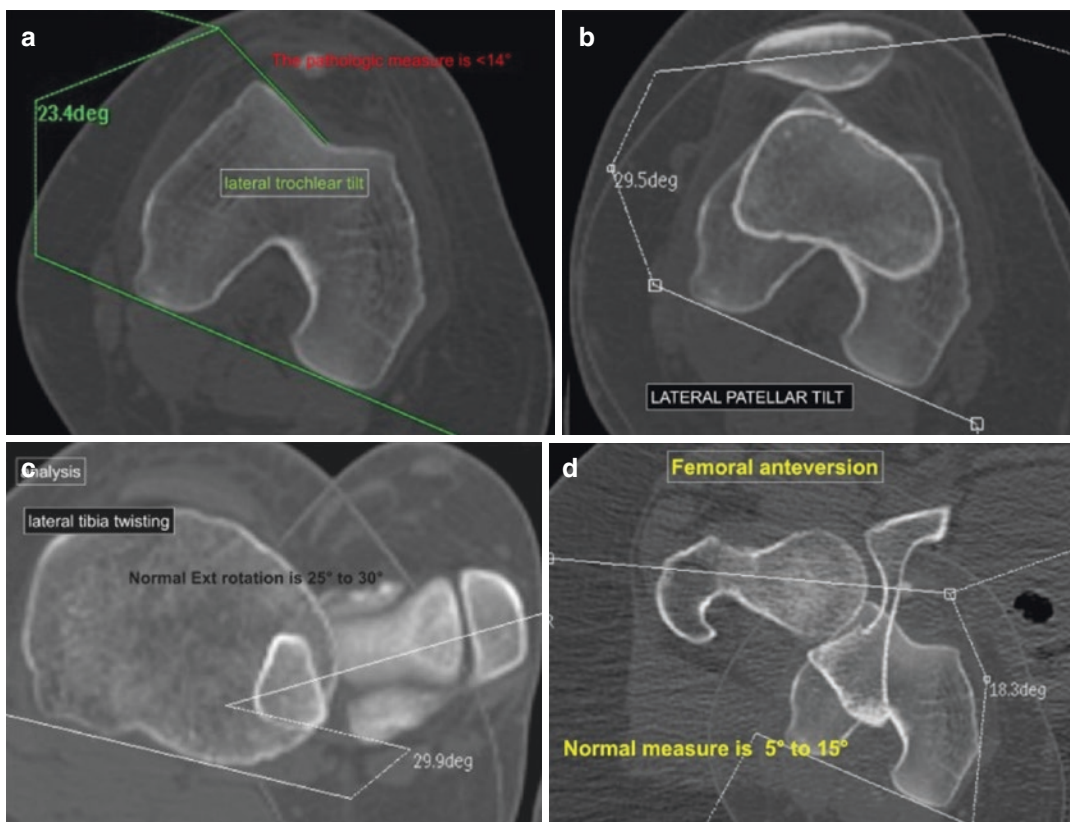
Rotational profile CT images to demonstrate the multiple anatomical factors involved in destabilising the patella, including (a) lateral trochlear tilt, (b) lateral patellar tilt, (c) lateral tibia twisting and (d) femoral anteversion
